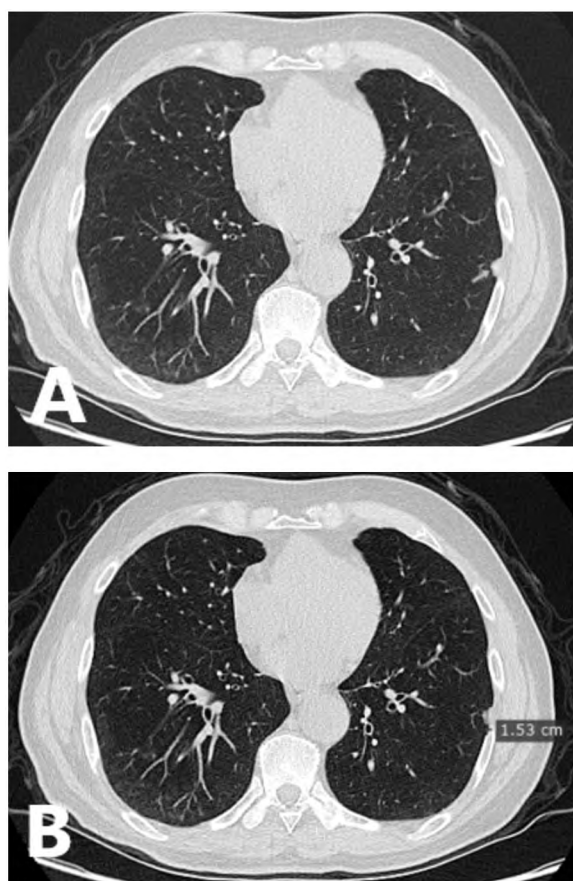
Male patient aged 78 years old, current smoker with normal chest X-ray. (A) axial pulmonary window LDCT chest screening with ASIR algorithm revealed pleural based soft tissue nodule seen in the lateral basal segment of the left lower lung lobe (green arrow). (B) Itmeasures about 15mm. According to the I-ELCAP diagnostic protocol, this nodule considered positive.
